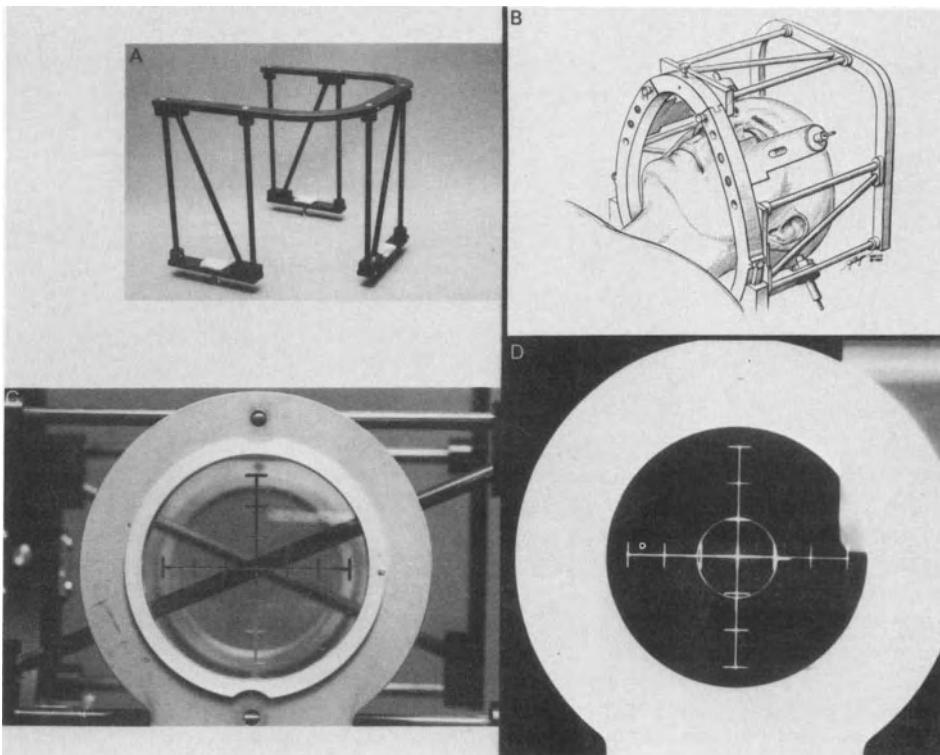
Localization system consisting of nine carbon-fiber rods. (B) System attaches to the CT head holder. The zero point of the localization system is identified visually (C) and by radiograph (D). X, Y, and Z frame settings are read from vernier scales on the stereotactic frame and retained in the computer as bias factors.
